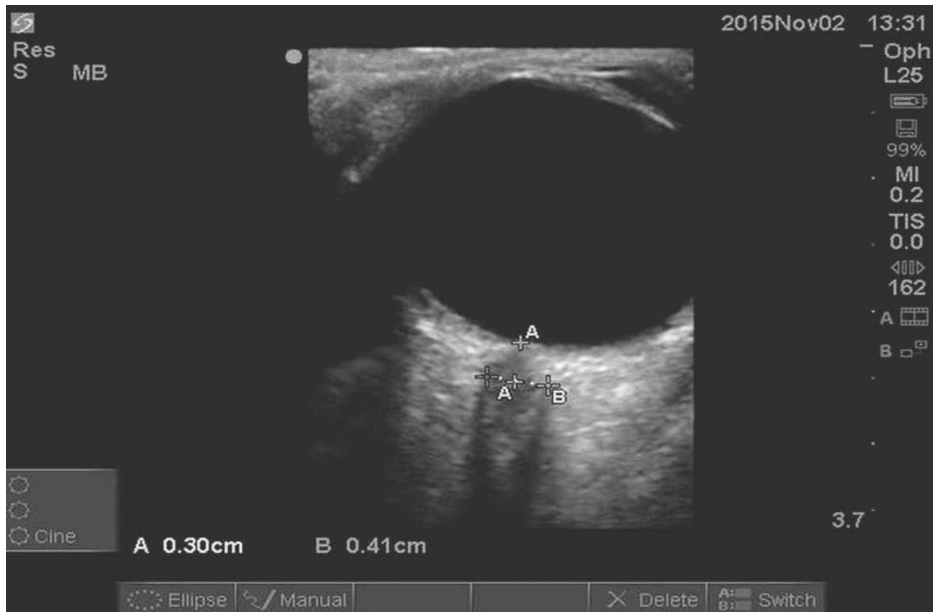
Sonographic image of an ONSD measured 3 mm behind the retina
